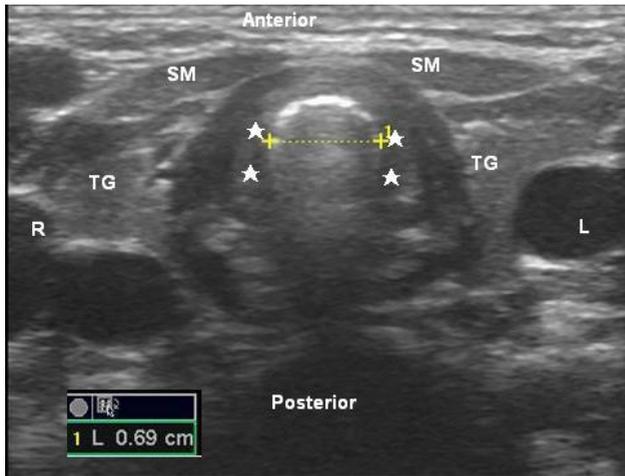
Transverse diameter of airway at the cricoids cartilage level in this patients measures 0.69 cm by ultrasonographic measurement. SM indicates strap muscle; TG, thyroid gland; asterix, cricoids cartilage.
